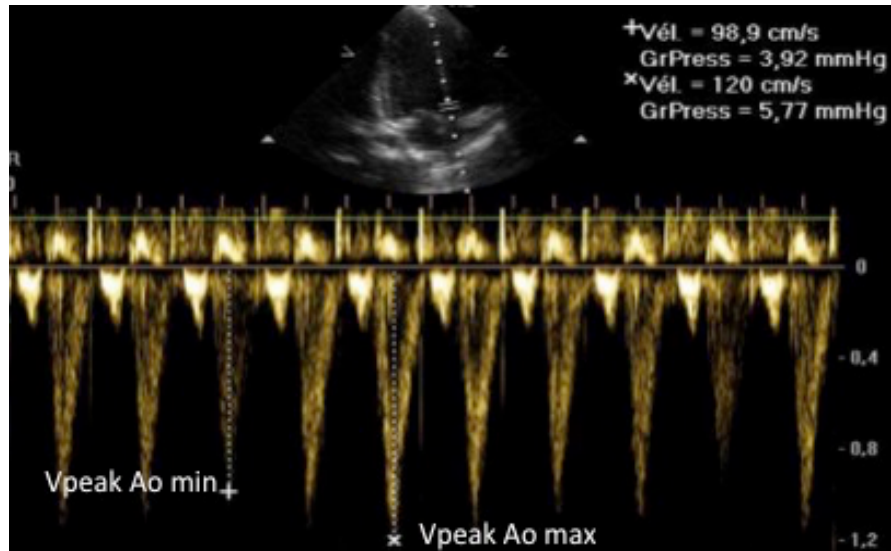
Measurement of Vpeak Ao maximum and minimum over one respiratory cycle using trans thoracic doppler. Reproduced from: Durand P et al. Intensive Care Med 2008;34:888–94.⁸²
